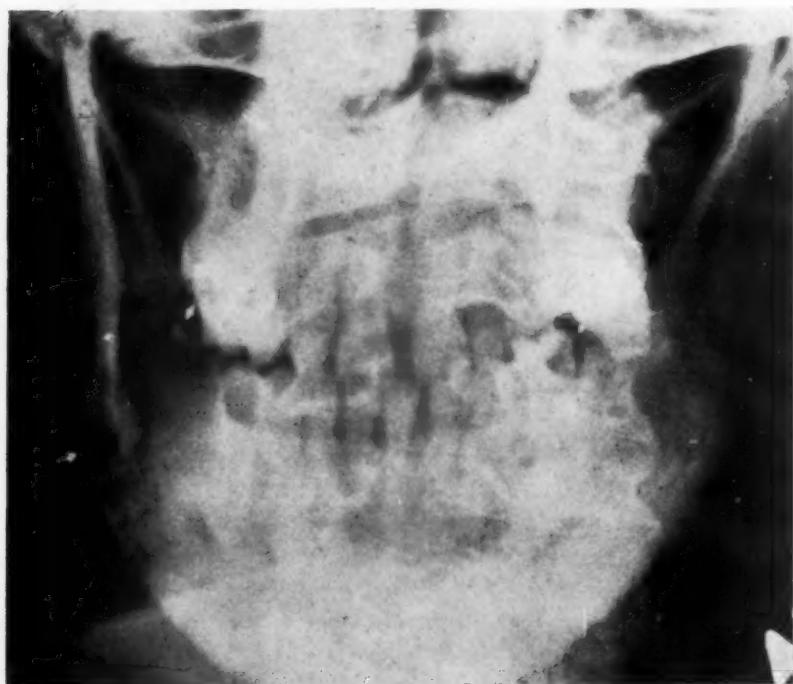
X-ray film showing osteomyelitis with pathologic fracture of left mandible.
